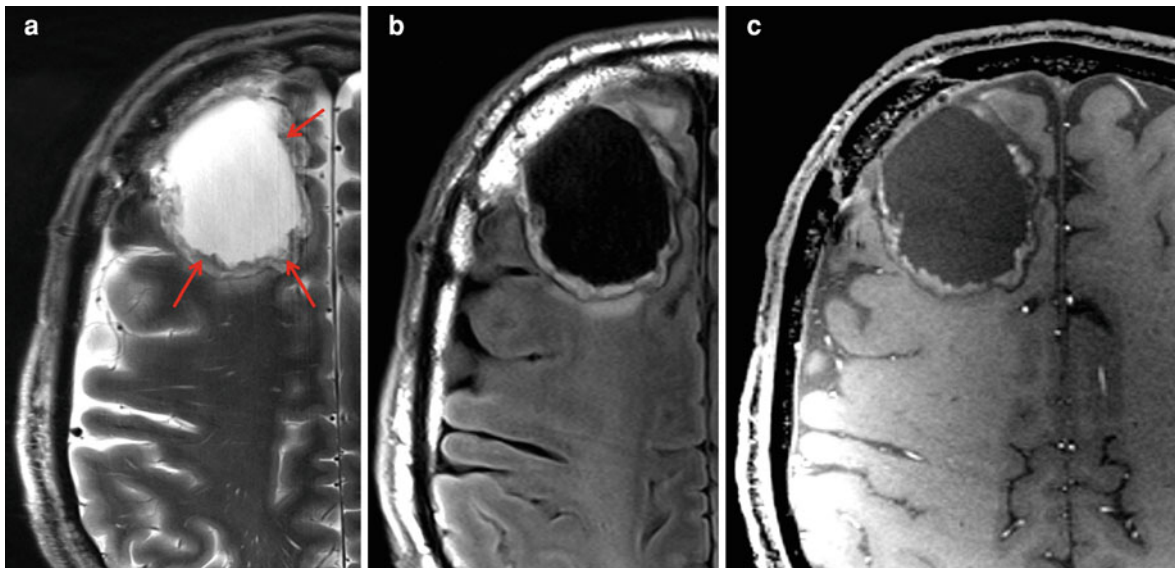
High-resolution morphological imaging at 7 T in T₂ (a, T₂-TSE, TR 12,000, TE 57 ms, matrix 768 × 624, FoV 220 × 179 mm, slice thickness 2 mm), FLAIR (b, TR 12,000, TE 83, TI 2,760 ms, matrix 512 × 298, FoV 230 × 179 mm, slice thickness 2 mm), and T₁ after i.v. Gadolinium
